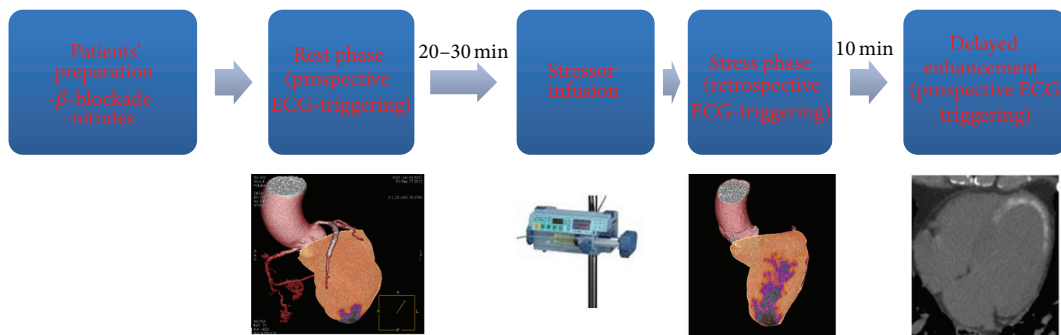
Scan protocol of stress cardiac computed tomography.
